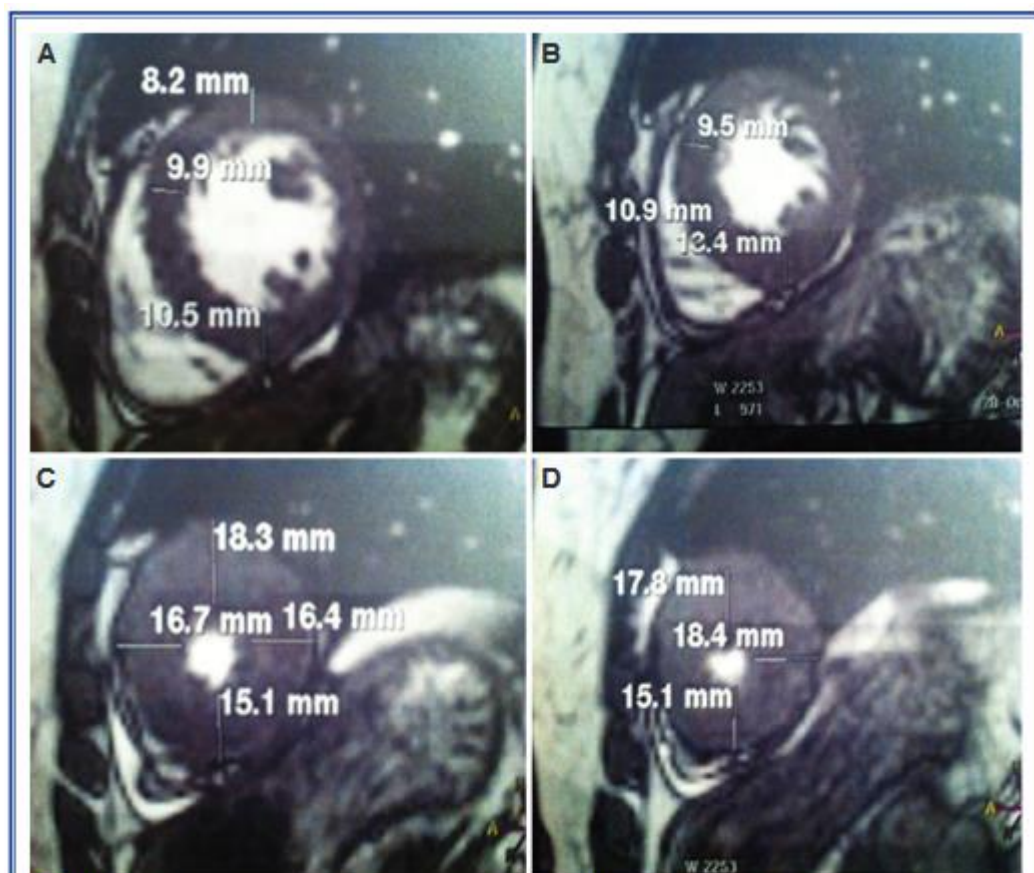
Cardiac magnetic resonance imaging: (A) basal left ventricular wall thickness (B) moderately increased left ventricular wall thickness and (C, D) apical left ventricular wall thickness
